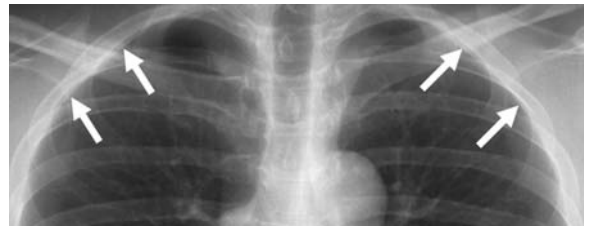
Postero-anterior chest radiograph shows the so-called companion shadow (arrows), which parallels the medial surface of the first three or four ribs and is most prominent along the second rib
